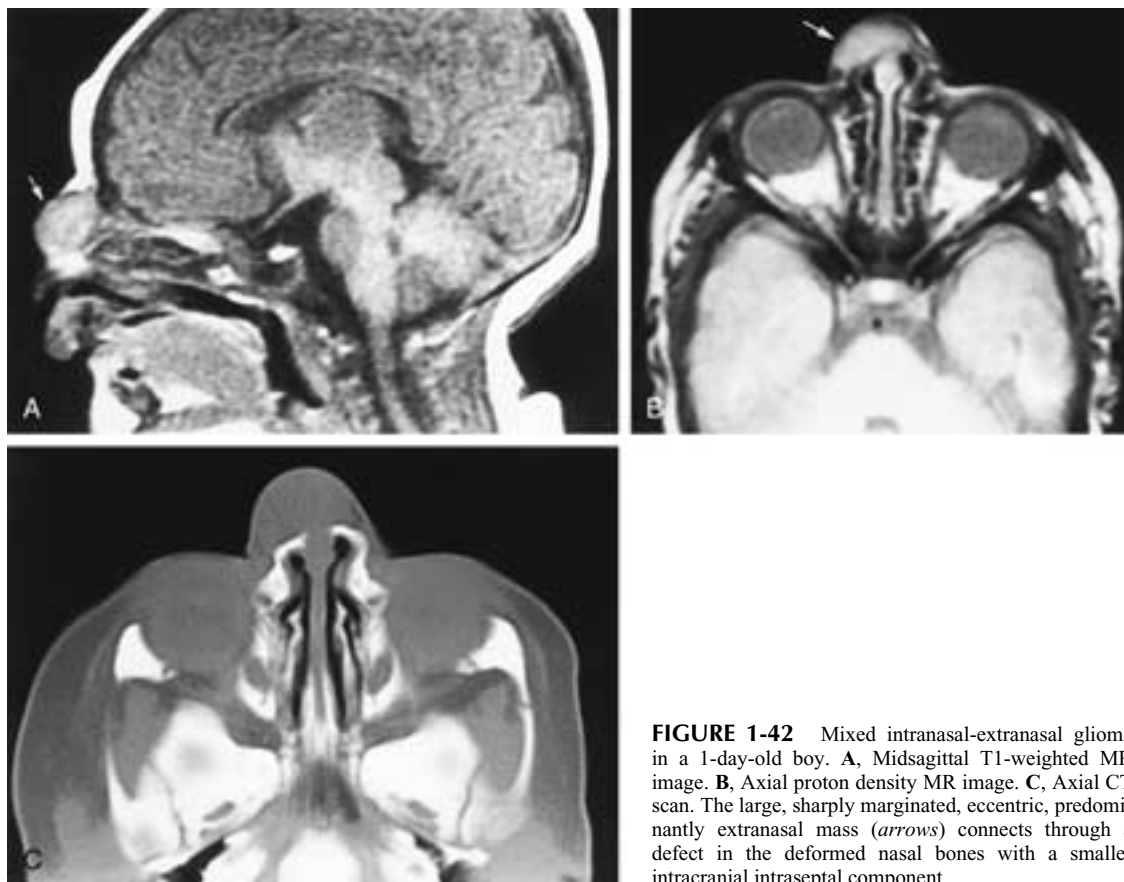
Mixed intranasal-extranasal glioma in a 1-day-old boy. A, Midsagittal T1-weighted MR image. B, Axial proton density MR image. C, Axial CT scan. The large, sharply marginated, eccentric, predominantly extranasal mass (arrows) connects through a defect in the deformed nasal bones with a smaller intracranial intraseptal component.
